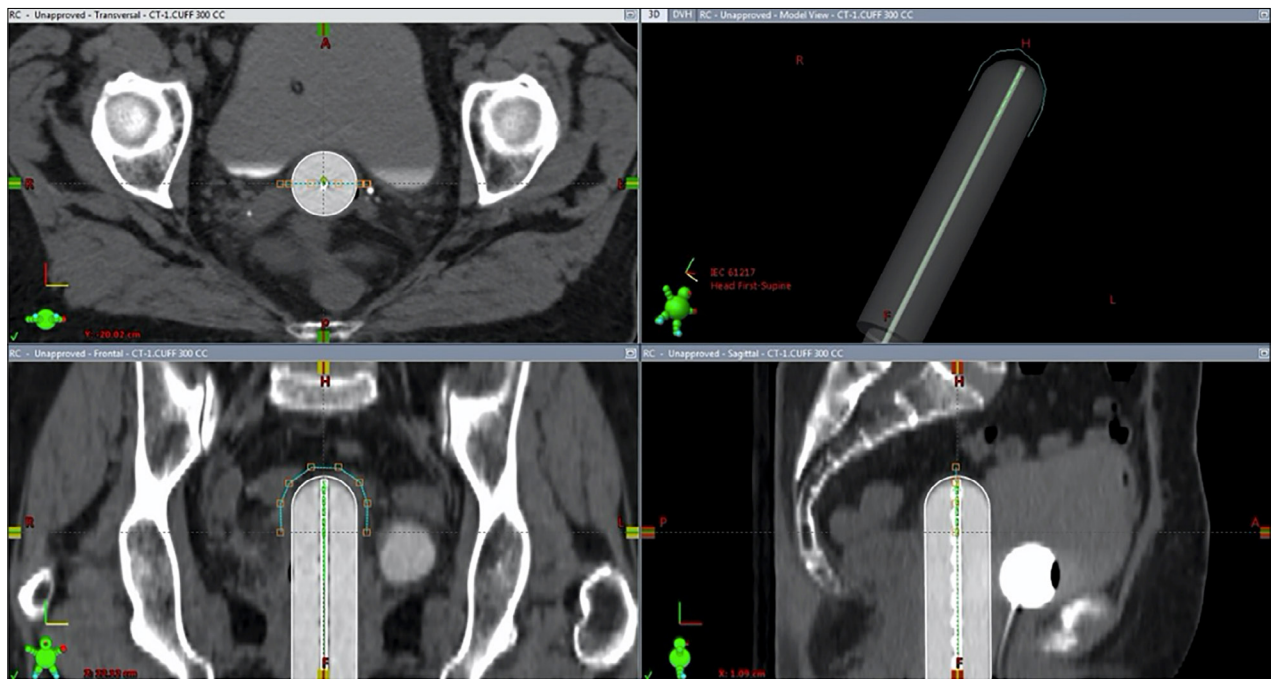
Determining the reference line in the computed tomography sections.
